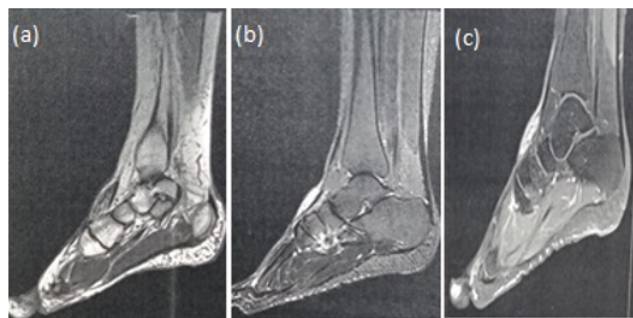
MRI showing homogenous soft tissue mass. T1 weighted image (a) shows subcutaneous nodular lesion in low signal, where it is enhanced by gadolinium (b). T2 weighted image (c) shows a high signal lesion.
